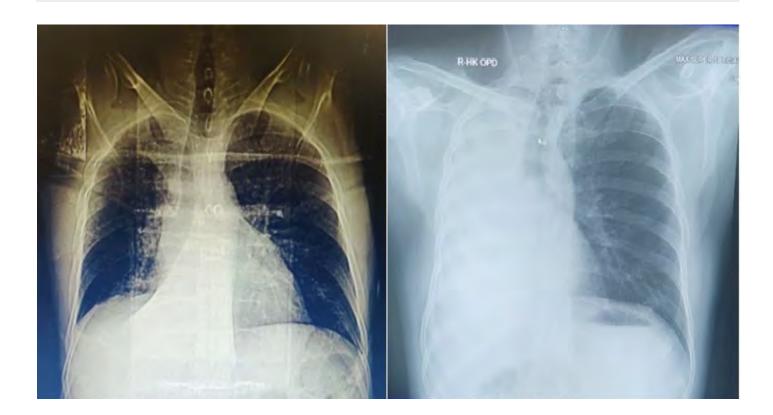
Chest X-ray of a patient with uncontrolled bronchial asthma, who had been diagnosed Hodgkin's lymphoma.
